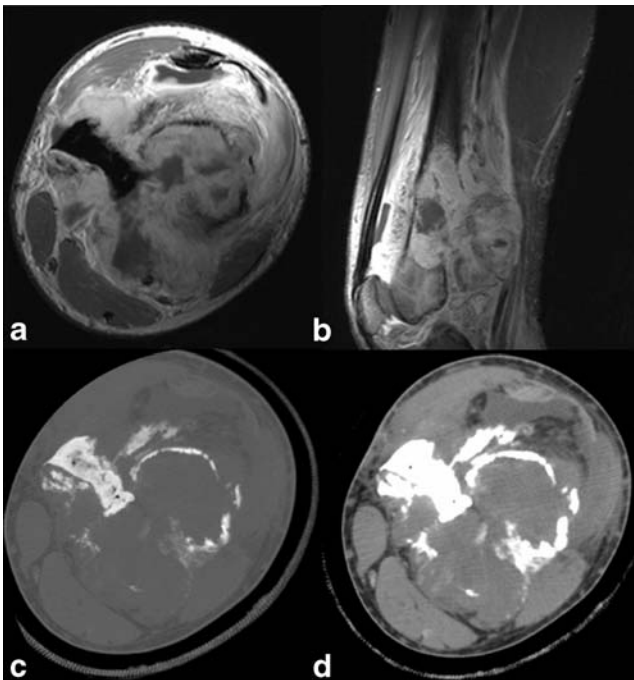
a Axial and b sagittal T1-weighted MRI shows the heterogeneous nature of the tumor, which involves the medullary cavity and surrounding soft tissue. The CT scan (c, bone window, d, soft tissue window) highlights the heavy ossification in areas of the tumor and its destructive nature
